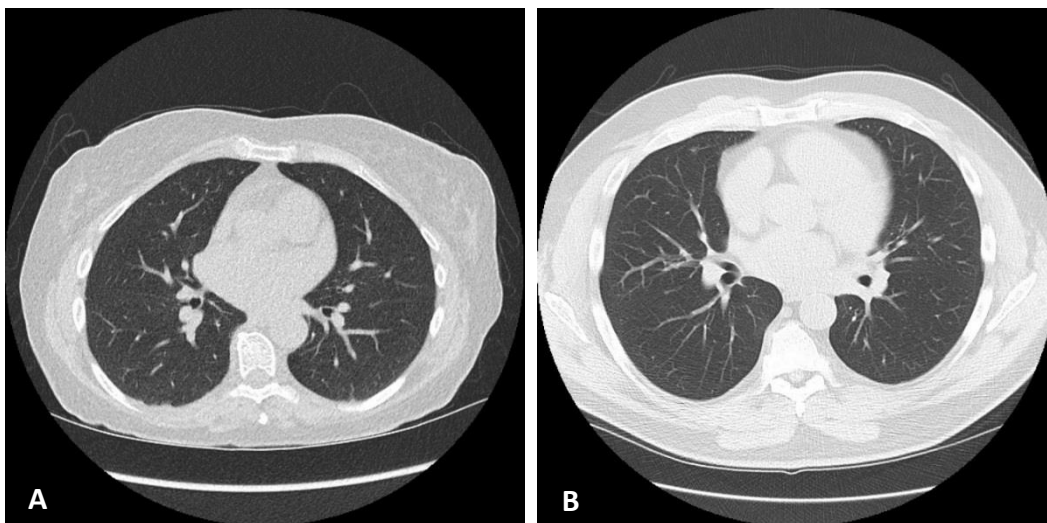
(A) LDCT with IR=0.5 mSv, (B) standard-dose CT with IR=4.0 mSv.
